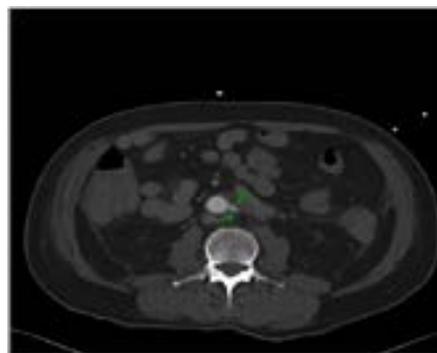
Computed tomography scan showing extravasation of iodine on the left aortic wall.
